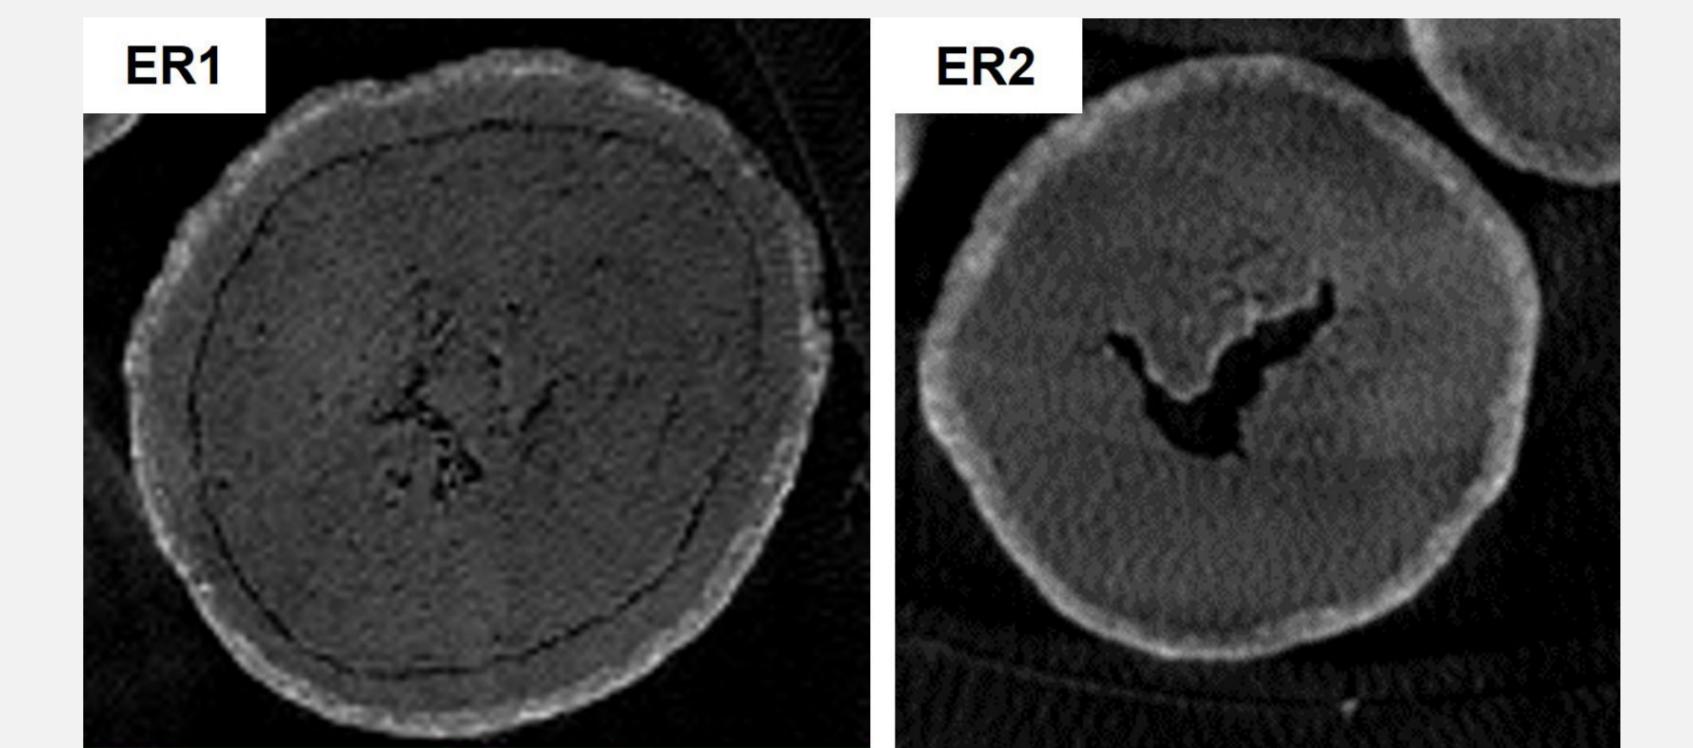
The micro CT image of ER1 and ER2 pellets.
